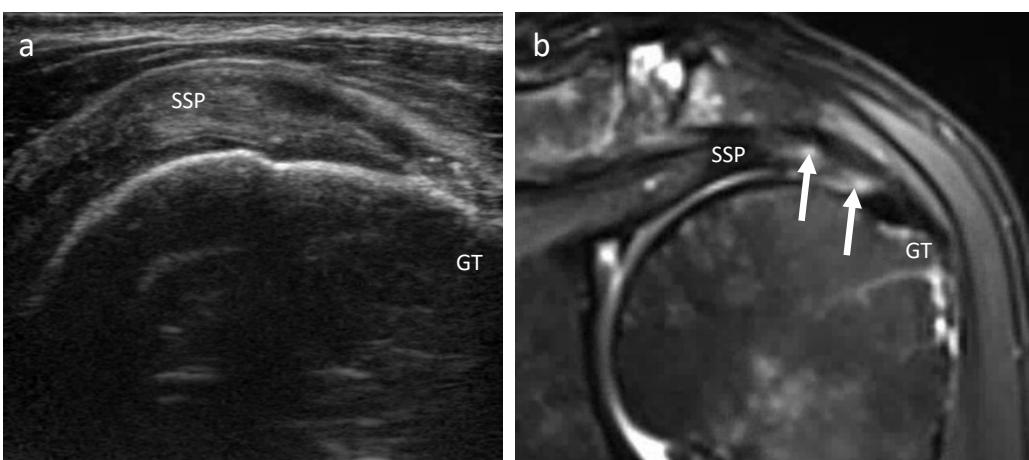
Ultrasonographic imaging underestimated partial-thickness supraspinatus tears. (a) Ultrasound (long axis) showed no tear of the supraspinatus tendon (SSP). (b) The oblique coronal T2-weighted fat-suppressed MRI showed an articular side tear (arrows) of the supraspinatus tendon (SSP). Abbreviations: GT = greater tuberosity
